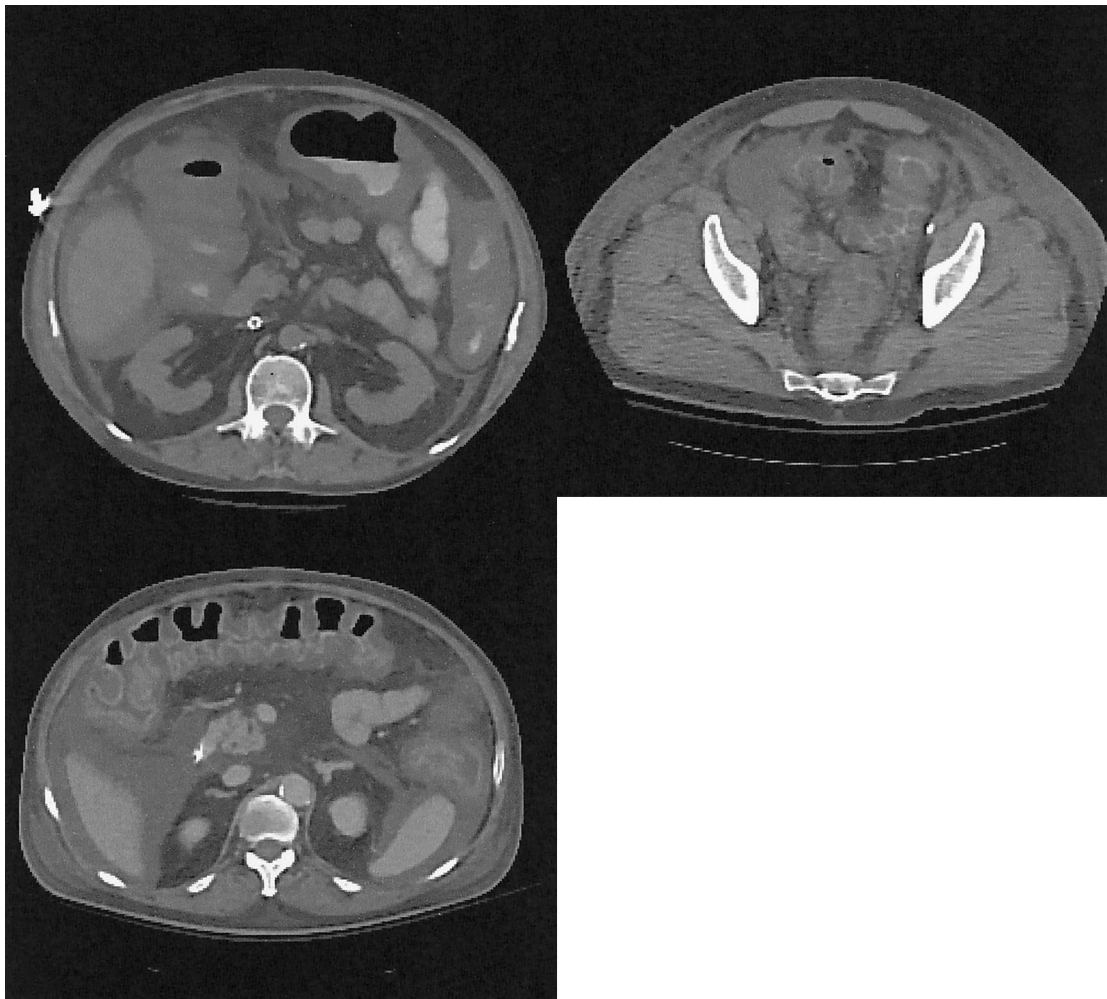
Abdominal computed tomography scans from three patients with findings diagnostic of fulminant *Clostridium difficile* colitis. Patients with systemic symptoms from *C. difficile* colitis in whom thickening and dilatation of the colon and ascites develop require a colectomy.
